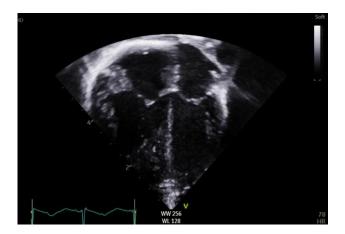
Four chamber echocardiographic view showing normal heart structure, dilated right atrium and right ventricles.
